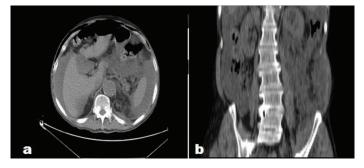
Images of non-contrast CT show abdomen filled with irrigation fluid after the intraperitoneal perforation
